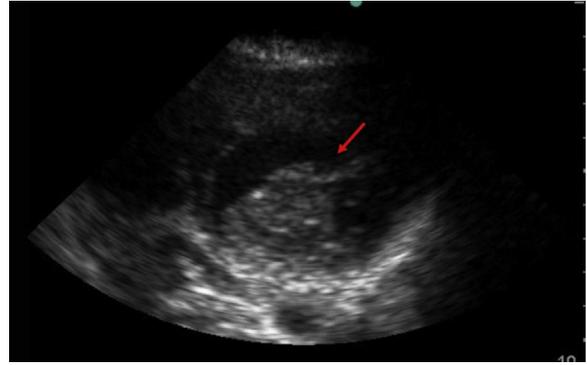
Parasternal short axis view showing a large mass in the left atria.
